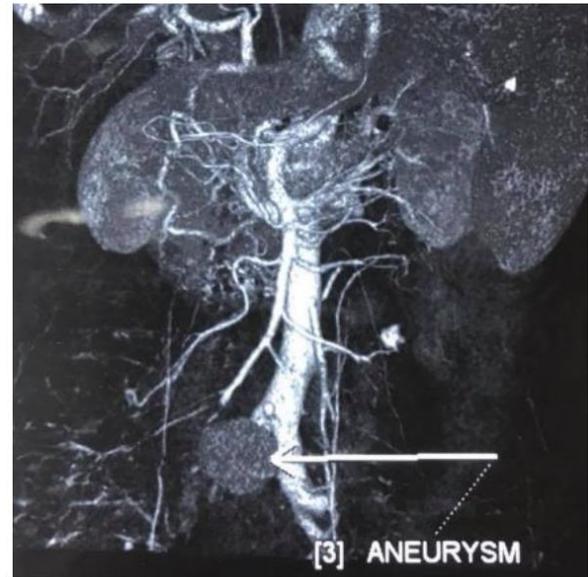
Abdominal CT-angiogram revealed a circumferential lesion, located anterior to aortic bifurcation suggestive of IMA mycotic aneurysm.
